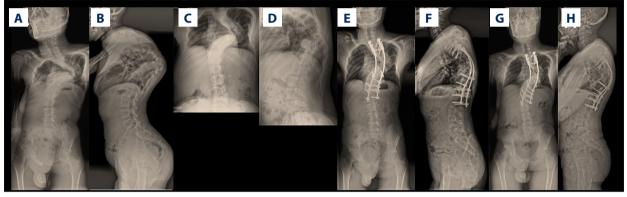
The posteroanterior (PA) and lateral computed X-ray images of the spine in a 16-year-old man with severe kyphoscoliosis. A 16 year-old male with severe kyphoscoliosis (A, B). The patient underwent preoperative halo-gravity traction for three weeks (C, D). Following surgery, the coronal and sagittal deformities were significantly corrected (E, F). At a two-year postoperative follow-up, no significant correction loss was found (G, H).
